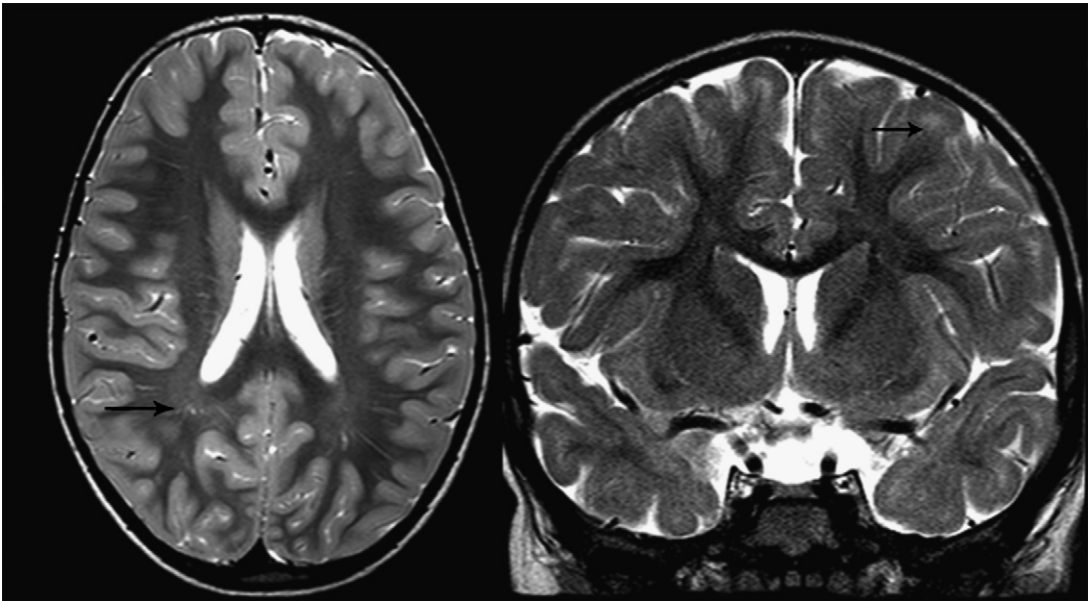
Axial and coronal T2-weighted sequences demonstrate normal terminal zones of myelination (*black arrows*). These zones are classically located in the posterior periventricular region as well as the frontotemporal subcortical regions.
